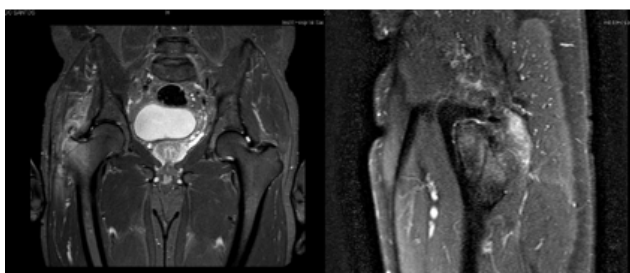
& 5 Coronal and sagittal MRI image – Intraosseous edema of the right greater trochanter, local inflammatory phenomena of the soft tissues adjacent to the greater trochanter, infratrochanteric fluid collection, with approximately 20 mm in greatest axis.
